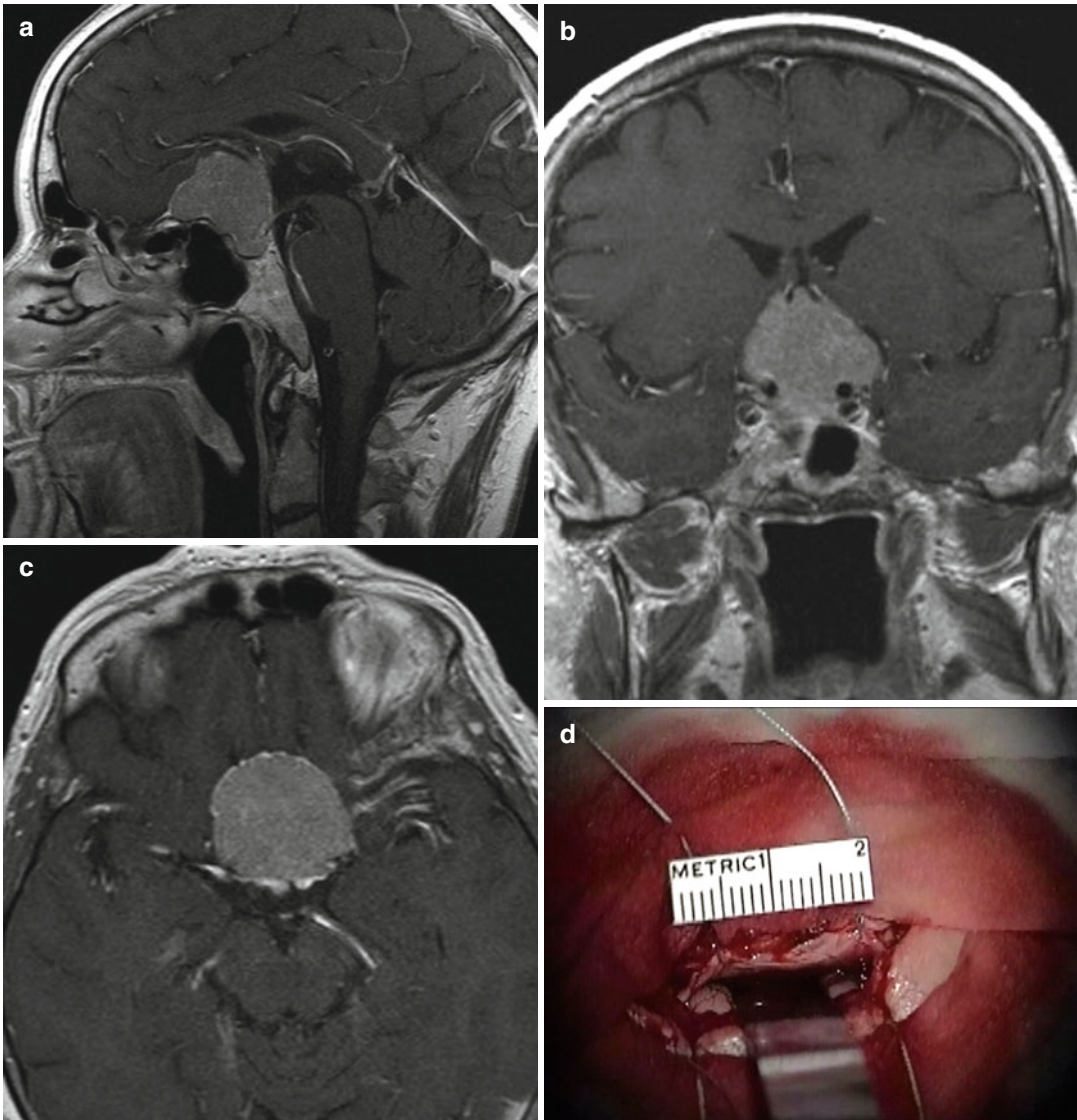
Tuberculum sellae meningioma in a 61-year-old female presenting with visual loss and visual field deficits. (a–c) Sagittal, coronal, and axial T1-weighted MR images showing a contrast-enhancing lesion arising from the tuberculum sellae. (d) Microsurgical approach via eyebrow incision and supraorbital craniotomy. (e) Microsurgical exposure of the right optic nerve (arrows) and tumor (T). (f) Endoscopic dissection of tumor remnants (T) at
